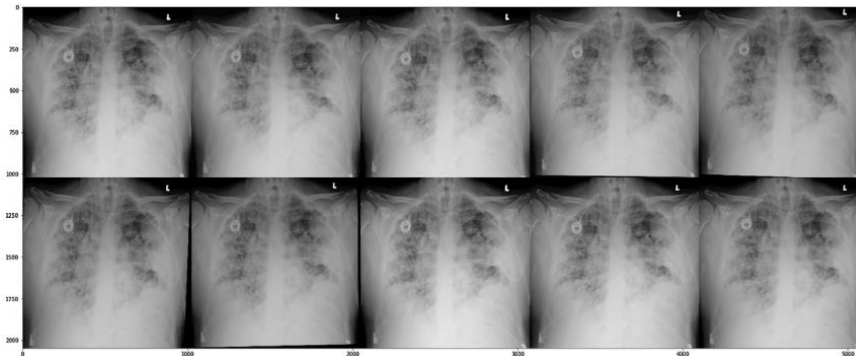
Augmentation on chest X-ray images.
